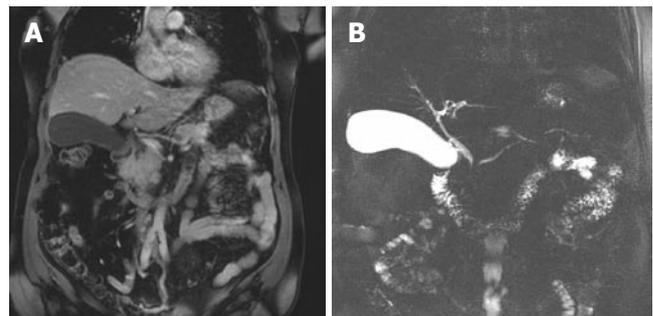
Coronal T1-weighted fat-saturated MR image demonstrates pancreatic head mass measuring 4.7 × 3.2 × 2.9 cm (A) and MRCP shows the stenosis of the pancreatic and bile duct (B).
